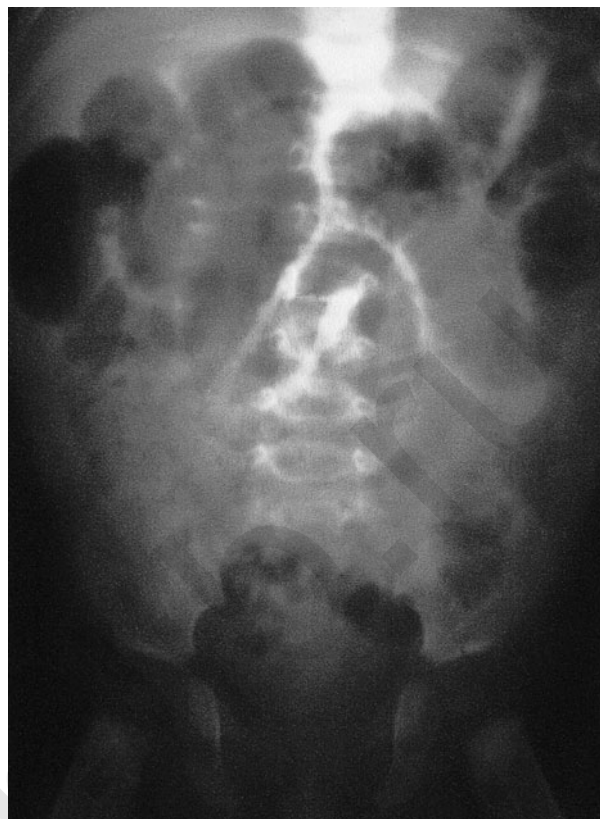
Plain x-ray showing distended loops of intestine and Neuhauser's sign.
